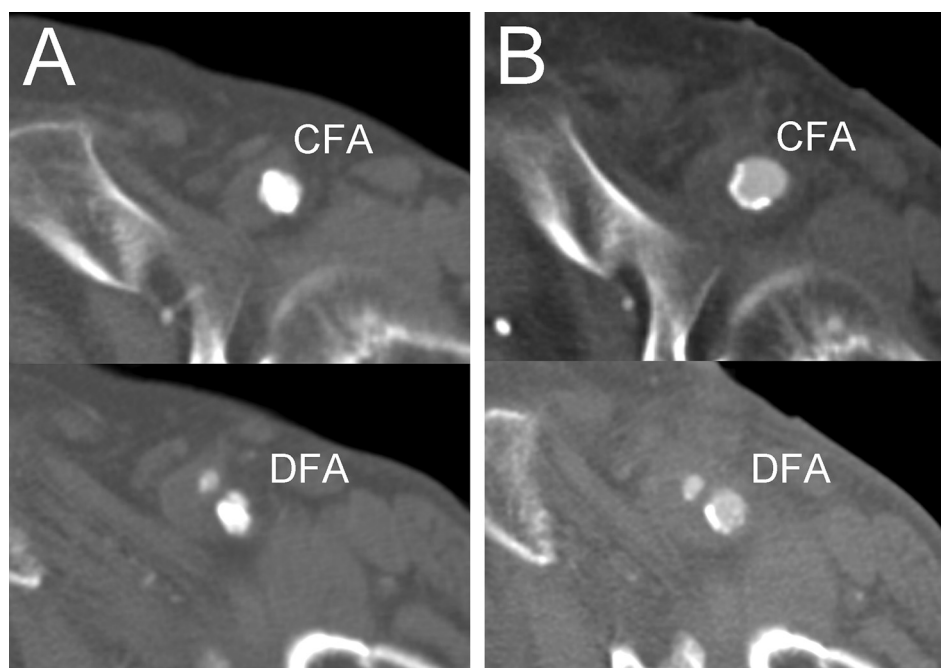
Pre- and post-operative computed tomography angiography findings. (A) Extensive calcification is evident in the common femoral artery (CFA) and deep femoral artery (DFA). (B) CFA and DFA after decalcification with the Cavitron ultrasonic surgical aspirator (CUSA) showing a fully restored vessel lumen. The diameter of the distal end of the treated lesion was approximately 5 mm.
